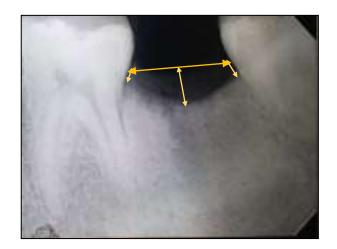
Height of bone- 180th day post operative radiograph with Arrows showing Central, mesial and distal linear measurements
